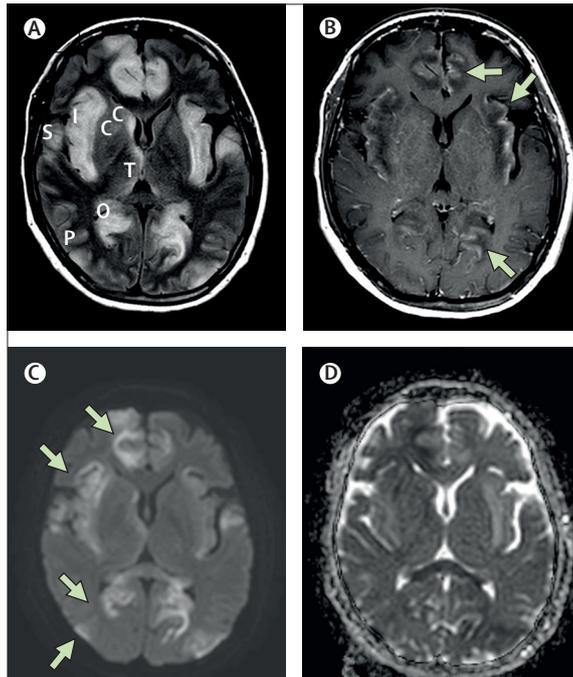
Brain MRI showing restricted diffusion and areas of subcortical oedema
